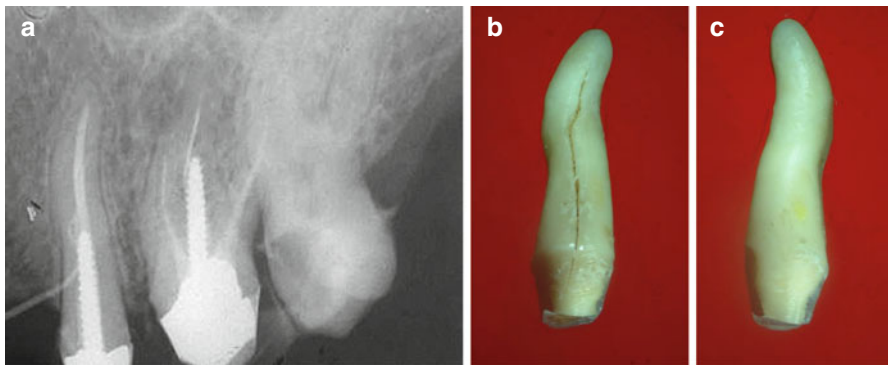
(a–c) The patient arrived at the dental office for a re-examination to replace two temporary crowns with permanent ones. Root canal treatment was performed 16 months earlier in a maxillary premolar, restored with a dowel and a temporary crown as well as in the maxillary molar. No radiolucencies in the bone surrounding the tooth could be detected in the radiograph (a). The patient initially declined to return to continue the restorative procedures. However, when he did return, there was a 9 mm probing defect in the midbuccal root and a highly located sinus tract. The gutta-percha tracing cone can be seen in the radiograph. The tooth was extracted. The incomplete VRF was found in the buccal side (b) but not in the lingual side (c)
